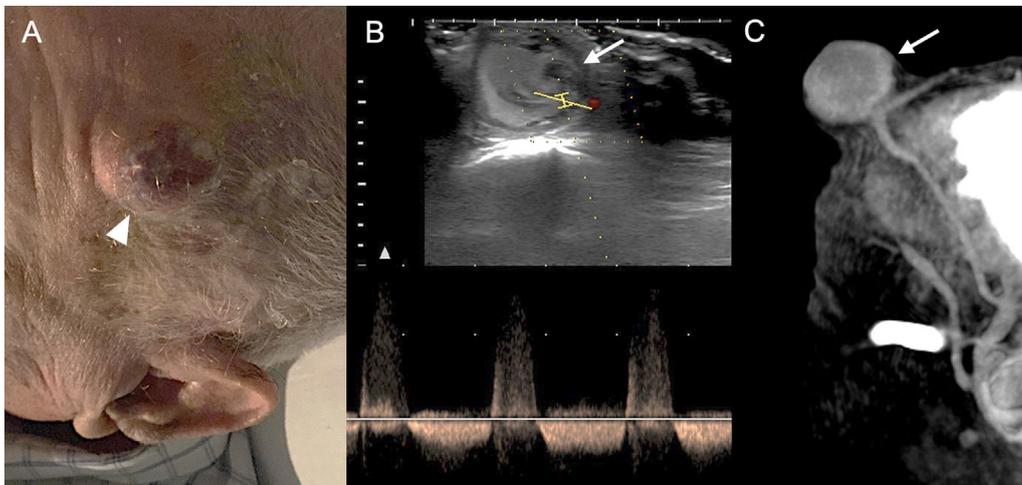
86-year-old man presenting with craniocerebral injury one month prior and since then a pulsatile mass in the left frontotemporal region of about 3 cm in diameter (arrowhead) (A). The ultrasound scan (B) shows an oval image arising from the left temporal artery with a sac with mobile internal echoes and turbulent flow consistent with a pseudoaneurysm of the left temporal artery (arrow), partially thrombosed and with bidirectional flow on spectral Doppler. The pseudoaneurysm can also be seen in the sagittal maximum intensity projection reconstruction of baseline brain CT (C).
